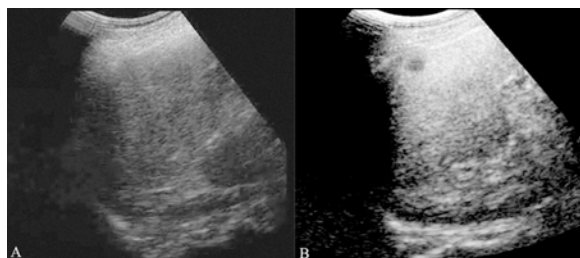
Splenic lesion inapparent on baseline sonography (conventional US image plus CEUS image taken at 57s from injection). A small subcapsular, hypoechoic nodule (arrow) becomes evident after contrast medium administration.
